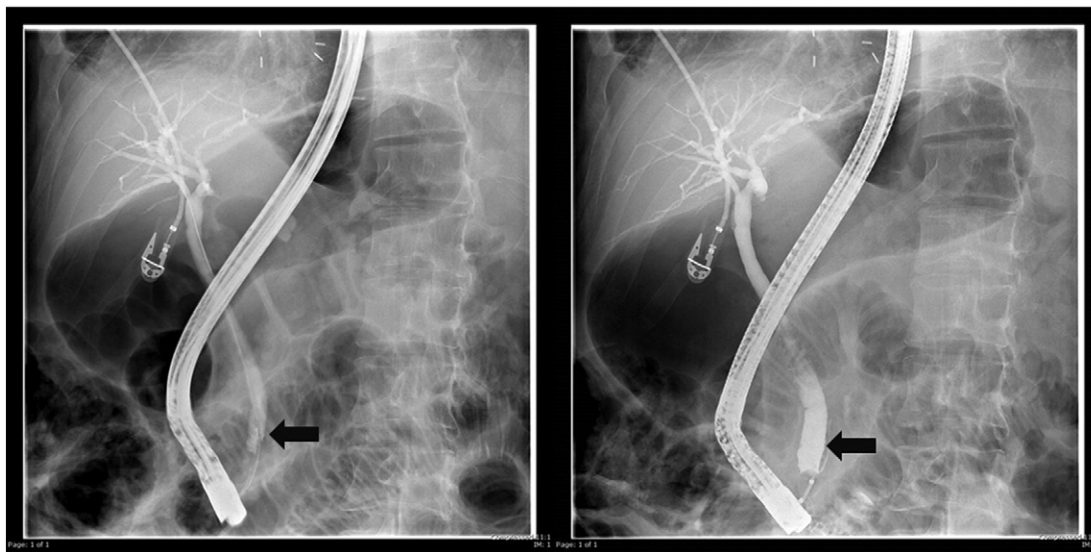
A 49 year-old man with CF and bilateral lung transplantation developed new liver enzyme abnormalities. He had known cholelithiasis and also a significant decline in lung function from chronic rejection that precluded cholecystectomy. MRI imaging suggested new CBD dilation and fluoroscopy images taken during ERCP revealed a filling defect in the distal CBD (left panel, arrow) due to choledocholithiasis. Following balloon sweep and extraction of the retained stone the filling defect fully resolved (right panel, arrow).
